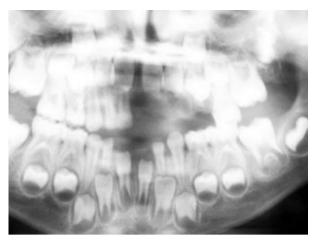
Radiographic examination: the avulsion of teeth 61–64, a residual root in the area of tooth 64 and bone fragments in the maxilla.
